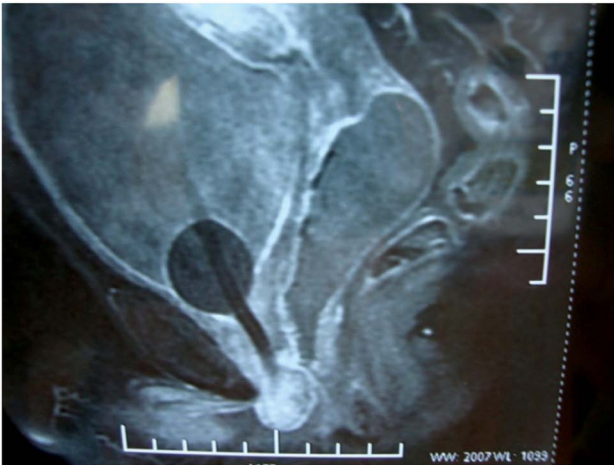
MRI Pelvis T2 weighted image STIR showing hyperintense image of tumour
